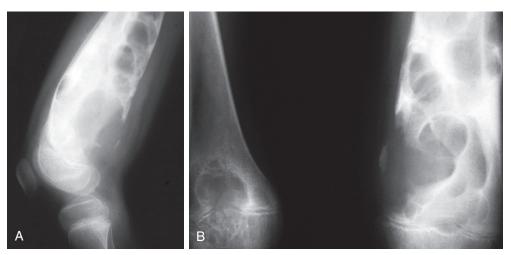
A, Pseudotumor of the femur. This radiographic finding has resulted from recurrent hemarthroses with subsequent bony destruction of the knee and adjacent bony structures. B, Note that the opposite knee also demonstrates early destructive changes in the distal femur and joint.
